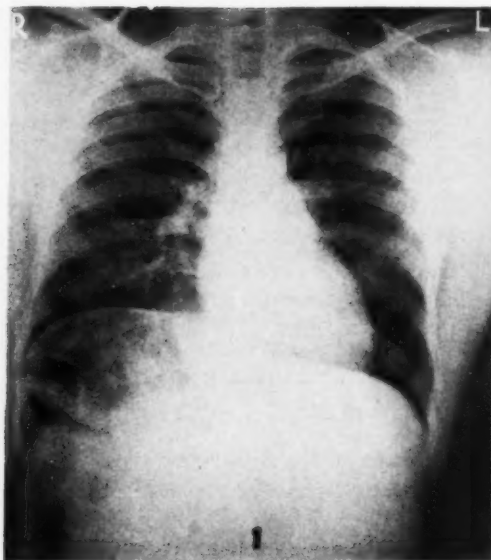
Chest roentgenogram showing normal position of the heart and elevation of the right diaphragmatic leaflet with accumulation of gas-filled bowel below it.
